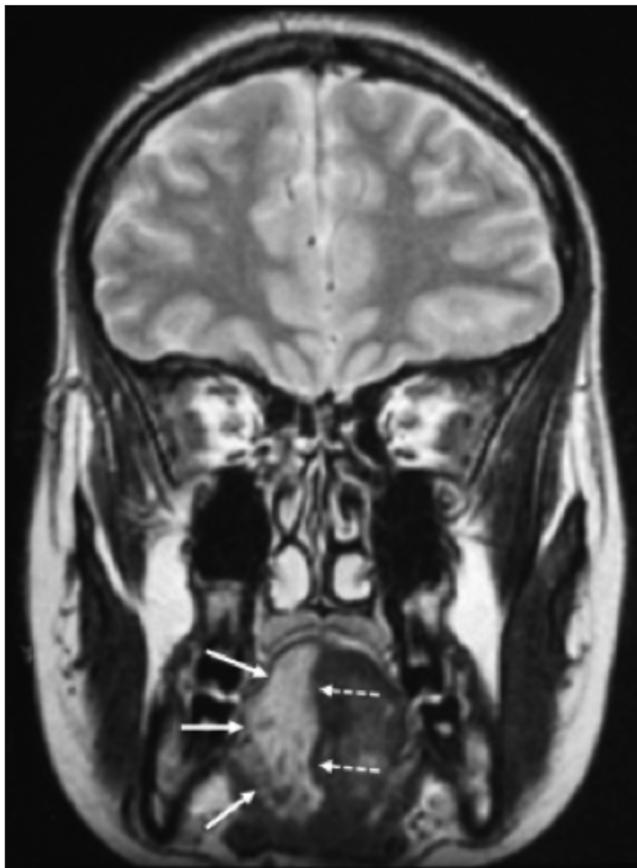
Coronal T2-weighted magnetic resonance image of the brain showing a hyperintense aspect of the right hemi-tongue (seen in the left side of the Fig.: white arrows), which is atrophic because of a schwannoma of the 12th cranial nerve (note the normal aspect of the contralateral tongue delineated by the dashed white arrows).
